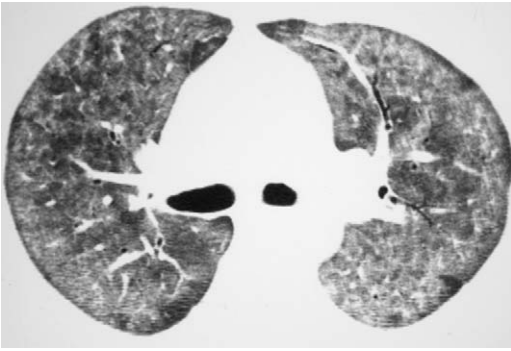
Ground-glass opacity on HRCT imaging: *Pneumocystis jirovecii* pneumonia. Axial HRCT image shows multifocal bilateral ground-glass opacity in a patient with AIDS, fever, and progressive shortness of breath. Sputum induction recovered *P jirovecii*.
